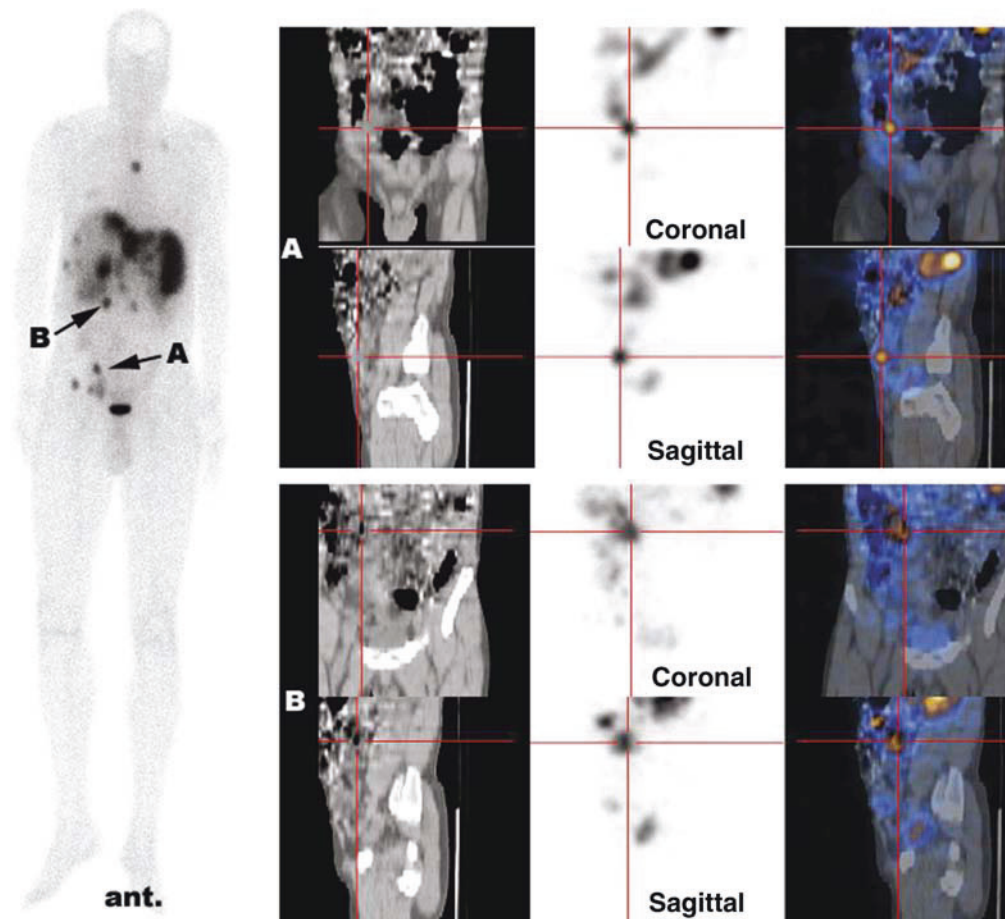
SRS whole-body scan (*left*) in a patient with metastatic thymic neuroendocrine tumor demonstrated several foci of increased ^{111}In -pentetreotide uptake in the chest, and right upper and lower abdomen. Selected coronal and sagittal SPET/CT slices showed the precise localization of one of the areas of abnormal uptake in the right lower abdomen (A) and in the right upper abdomen (B). Fused images (*right*) enabled metastatic lesions. (*see Color Plate 11*)
